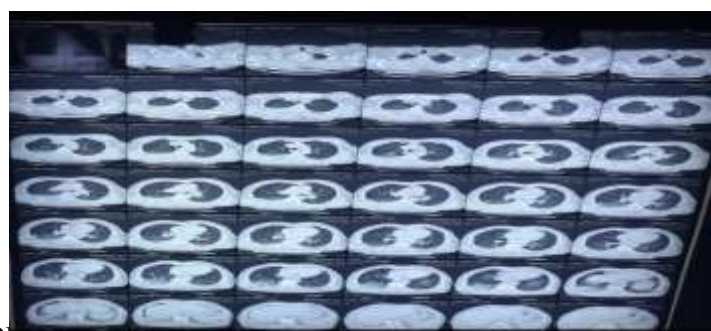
CT THORAX showing right sided pleural effusion with right lower wedge-shaped opacity
